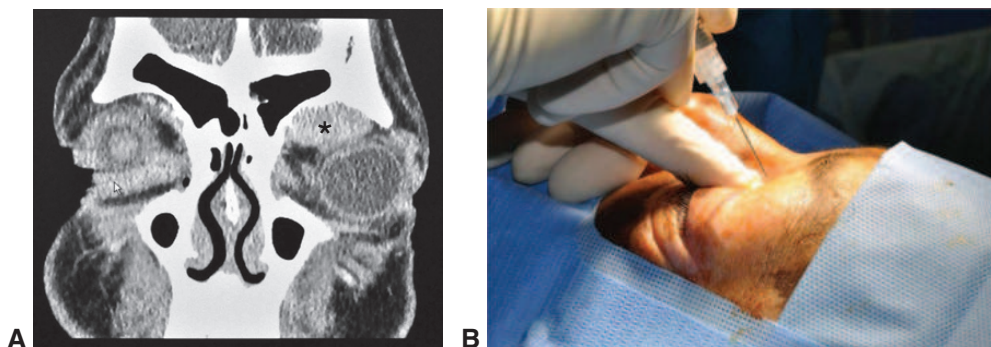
Fine-needle aspiration biopsy (FNAB). A, Coronal CT image of a left extraconal superomedial orbital mass (*asterisk*). B, FNAB is performed to avoid significant blood loss from an open biopsy and reveals metastatic hepatocellular carcinoma. (Courtesy of M. Reza Vagefi, MD.)
